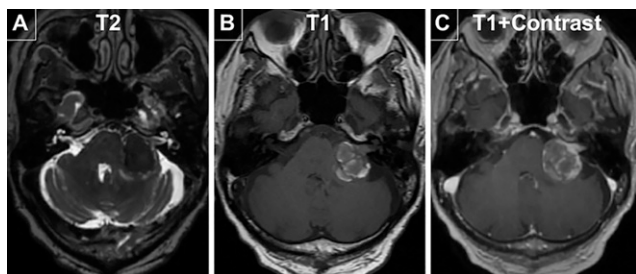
Preoperative imaging. A: T2-weighted MRI shows a hypointense solitary mass compressing the left side of the cerebellum. B: T1-weighted imaging shows intrinsic signal concerning for intratumoral hemorrhage. C: T1-weighted imaging with contrast shows extension of the tumor into the IAC.
